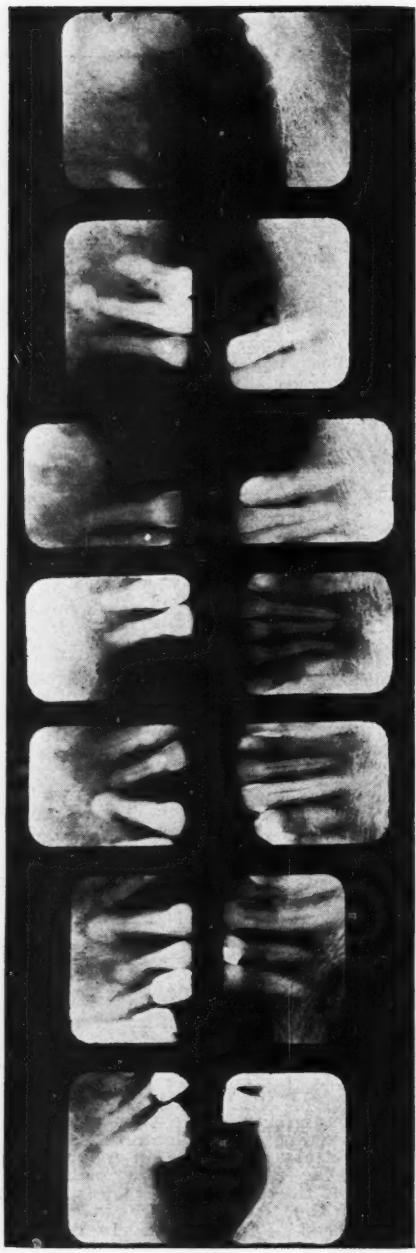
Intraoral roentgenograms showing primary chronic osteomyelitis of maxilla, involving all the teeth.
